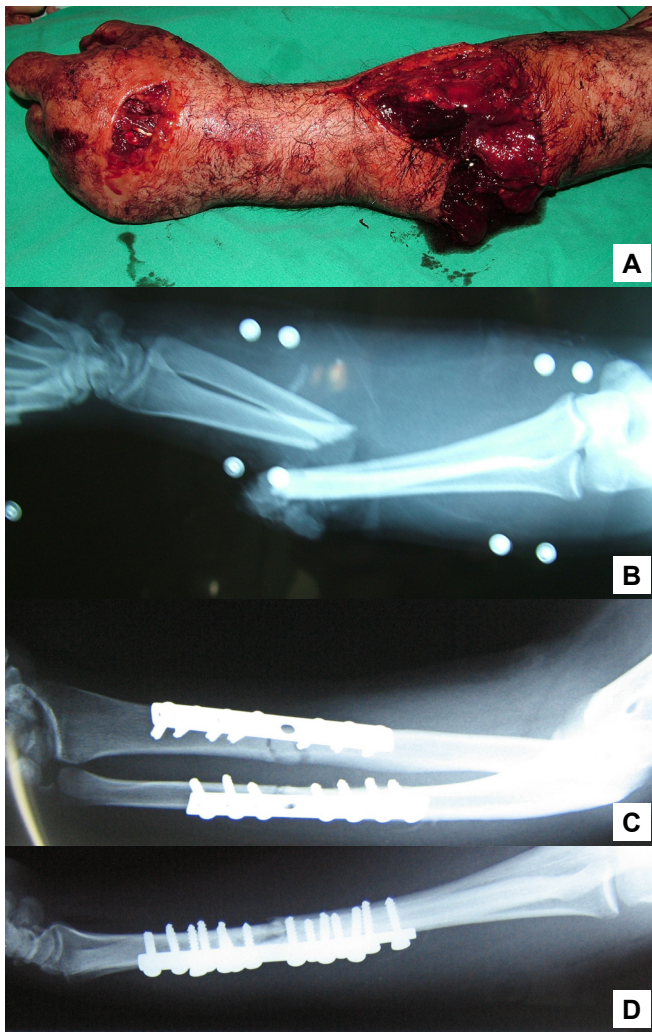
(A) 29-year-old man with a crush injury that occurred after an occupational accident. (B) Preoperative AP X-ray views. (C-D) Postoperative 1st day AP and lateral X-ray views.
